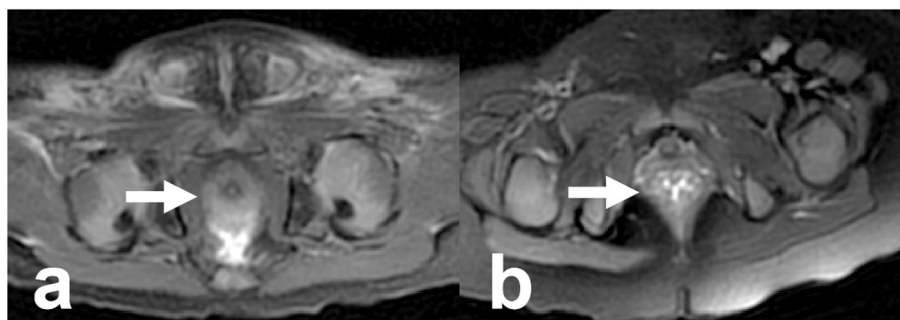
Representative fistula in axial fs T2WI MR images. a. ARM. b. Healthy rectum.
